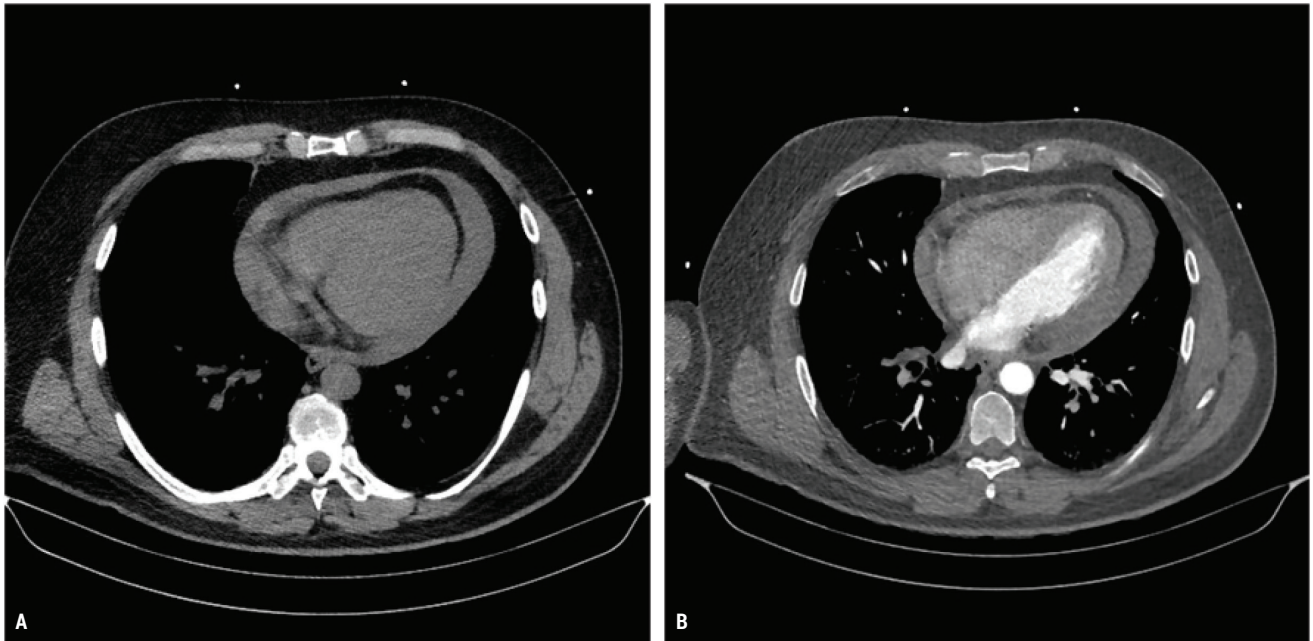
CT examination of acute aortic syndrome upon clinical request. A) axial non-contrast CT scan with hyperdense fluid in the pericardium; B) CT aortography, axial scan with contrast in the left atrium and ventricle and with pericardial effusion.
